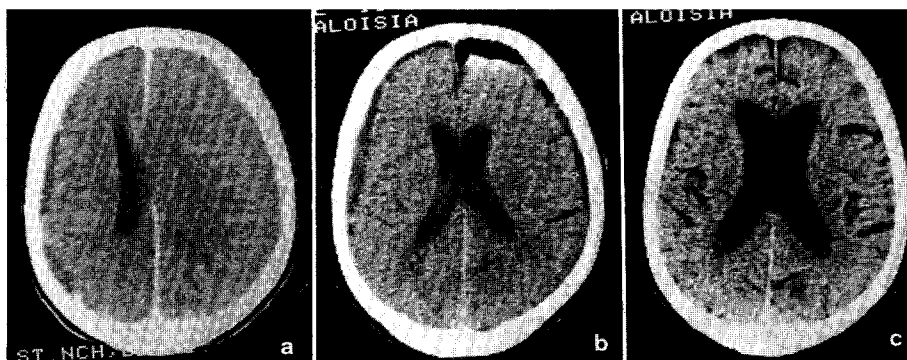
(M. A., 72 years.) Bilateral chronic subdural haematoma. CT on admission shows isodense haematoma over the right and hypodense haematoma over the left hemisphere (a). CT controls three days (b) and nine months (c) after surgery revealed gradual brain expansion
